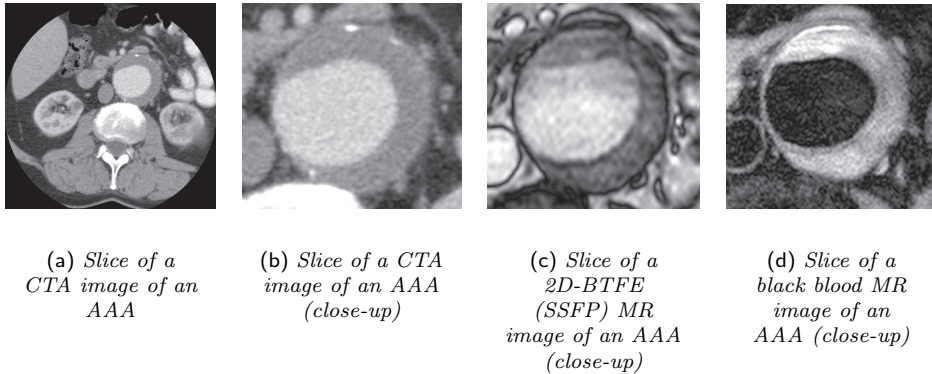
CTA and non-contrast enhanced MR images of abdominal aortic aneurysm. CTA gives very good contrast for the AAA lumen and has superior resolution. MR offers a better visualisation of the outer vessel wall and it provides better contrast for the different structures inside the thrombus.
